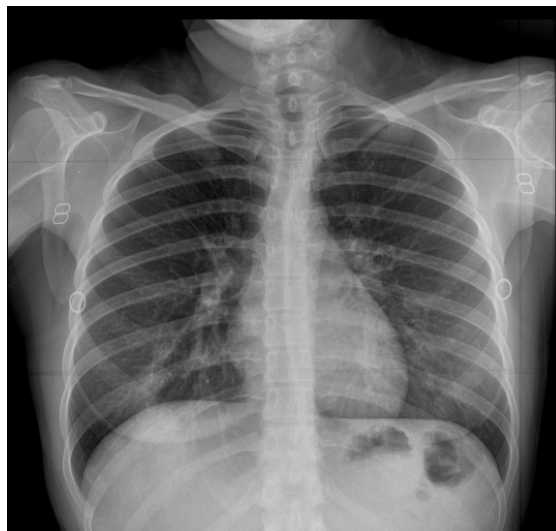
Postero-anterior chest X-ray was normal
